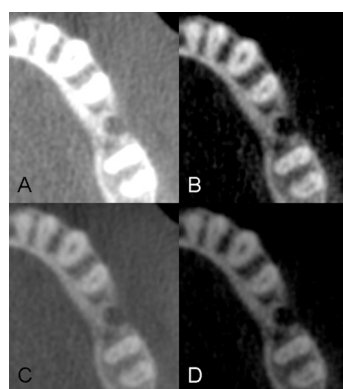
Four windowing protocols applied to the same single axial slice from I-CAT cone beam computed tomography
